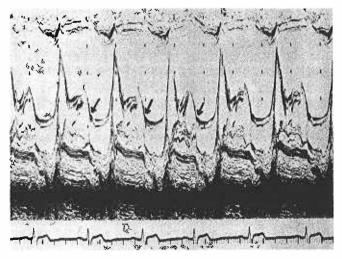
Echocardiogram of a patient with the prolapsing mitral valve syndrome. Arrows indicate the beginning of systole. There is obvious pansystolic prolapse of both mitral valve leaflets. (See text).
